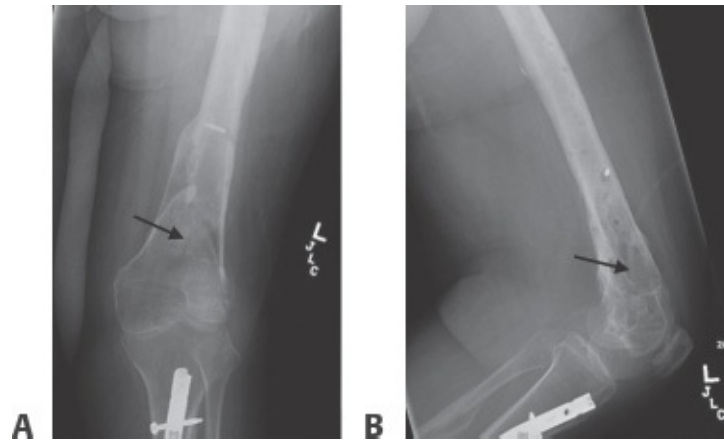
• A. AP and lateral (B) radiographs of a distal femur chronic osteomyelitis in the setting of prior internal fixation for an open distal femur fracture. Original hardware removed with exception of a broken screw. Radiolucent changes (*arrows*) seen in the metaphysis of a patient with clinical evidence of a draining sinus tract.
